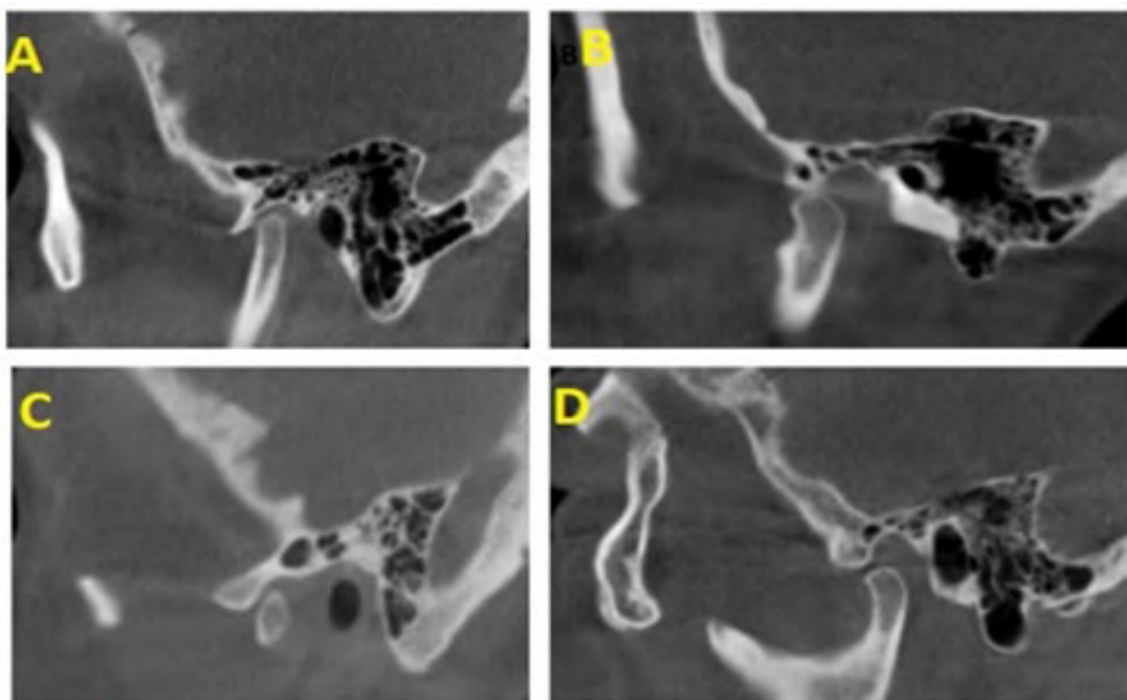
Multilocular ZACD in CBCT images.
